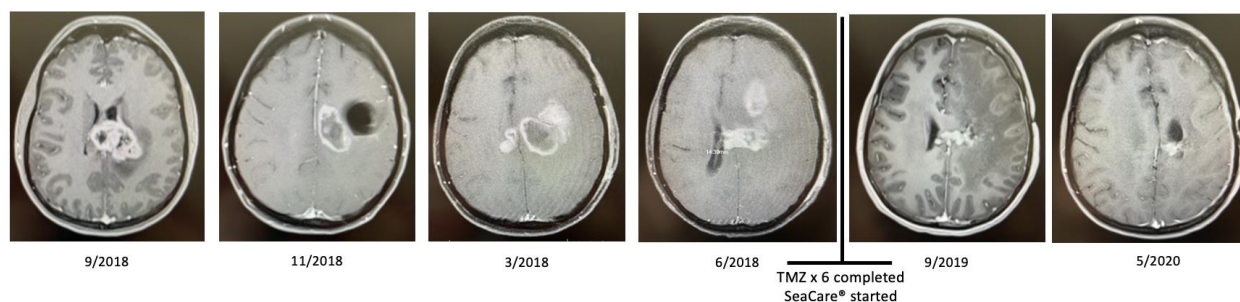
Serial radiographic response of Patient 2. Though the patient had a complicated clinical course, gadolinium-enhanced MRIs show a significant improvement in tumor size after completing 6 cycles of adjuvant TMZ and initiating marine nutraceutical products.
